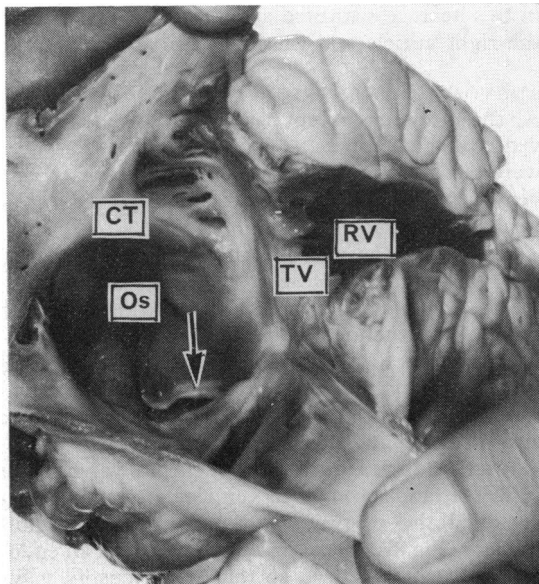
Case 2. The right atrium and right ventricle (RV) are hypoplastic. The septum primum (arrowed) is seen as a rim of tissue 2 mm in depth. The os of the right auricle (Os) appears at first sight to be a defect of the atrial septum. CT=crista terminalis; TV=tricuspid valve.
